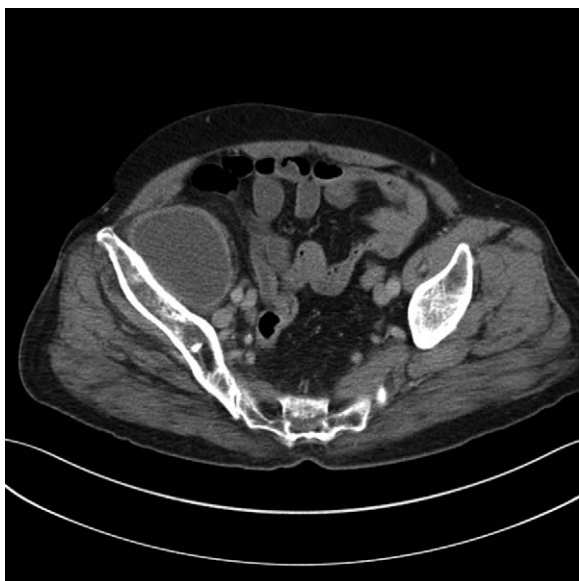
Pelvic CT scan revealed abscess-like cyst in the iliacus muscle.
